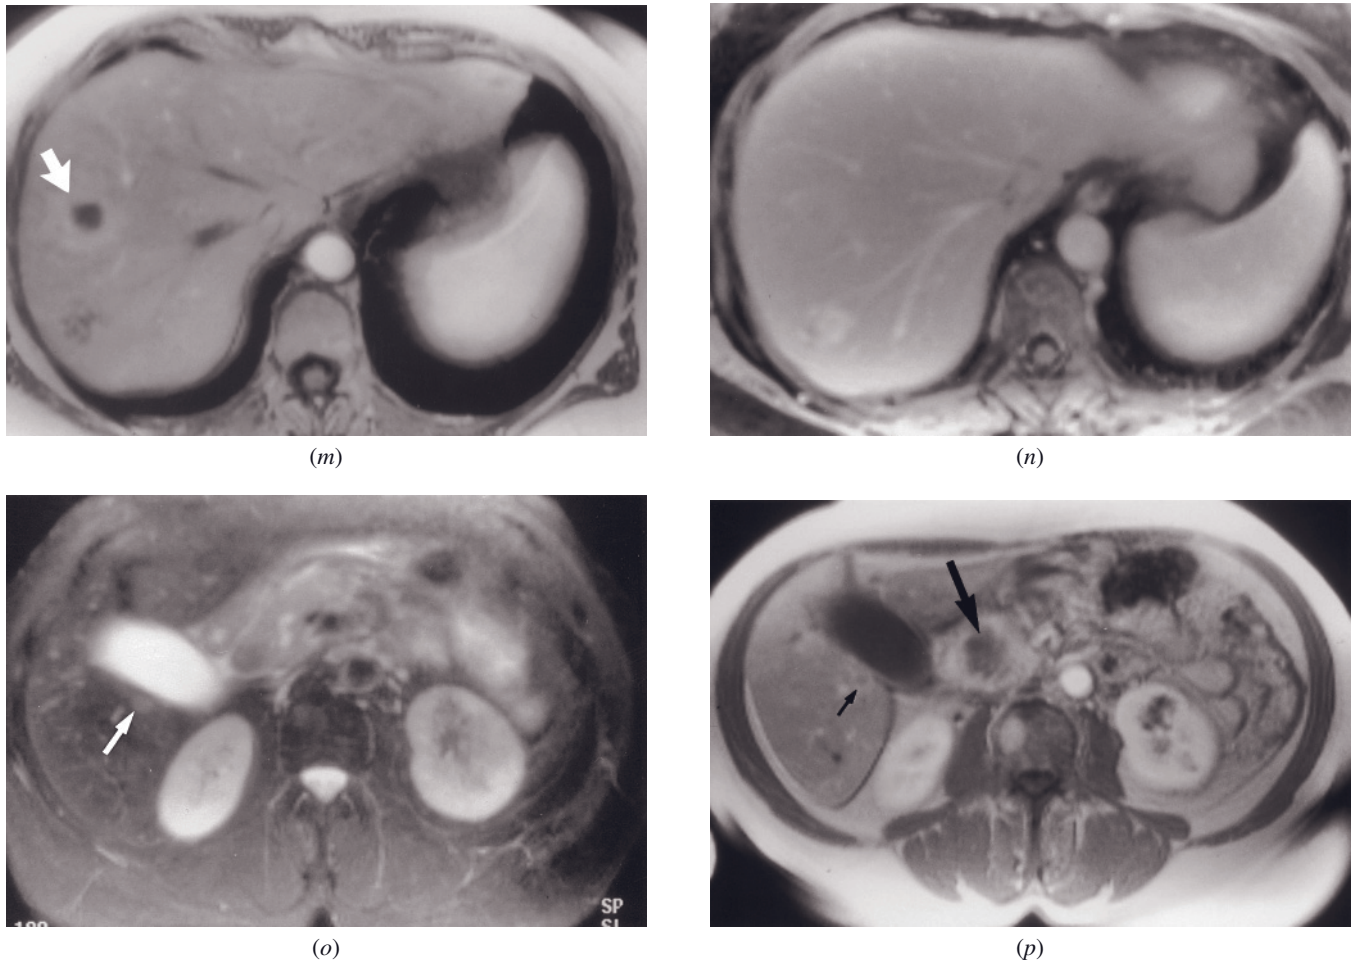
(Continued) fat-suppressed SGE (*n*) images in a sixth patient who has liver metastases and a hemangioma. Hemangiomas and metastases can usually be readily distinguished. The hemangioma (arrow, *l*) is high signal on T2 (*l*) and demonstrates peripheral nodules on the immediate postgadolinium image (*m*) with relatively uniform hyperintense enhancement on delayed images (*n*). In contrast, the 3-cm metastasis is nearly invisible on T2 (*l*) and late postgadolinium images (*n*), with intense ring enhancement (arrow, *m*) on immediate post-gadolinium image (*m*). This constellation of findings is virtually pathognomonic on T2-weighted and postgadolinium images for a liver metastasis coexistent with a hemangioma.
